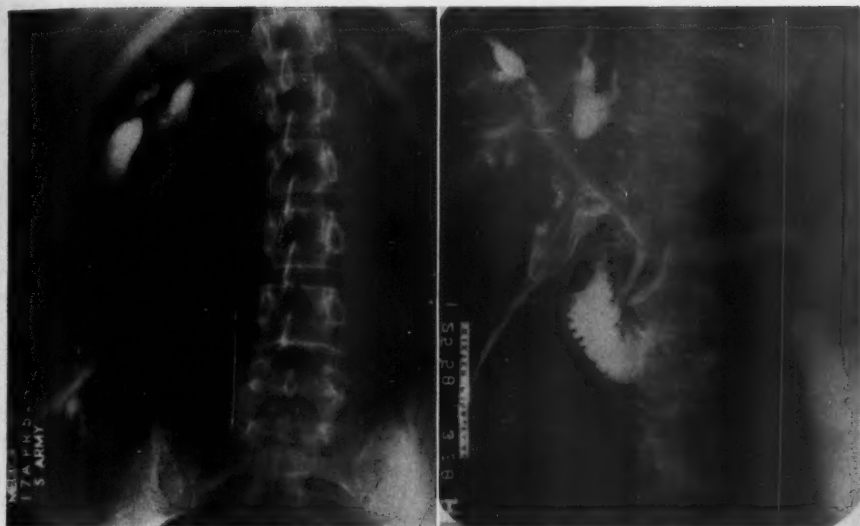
(Left). Roentgenogram from case no. 1, showing a fistulous connection between a compound fracture site of the right iliac bone with the gall bladder.
